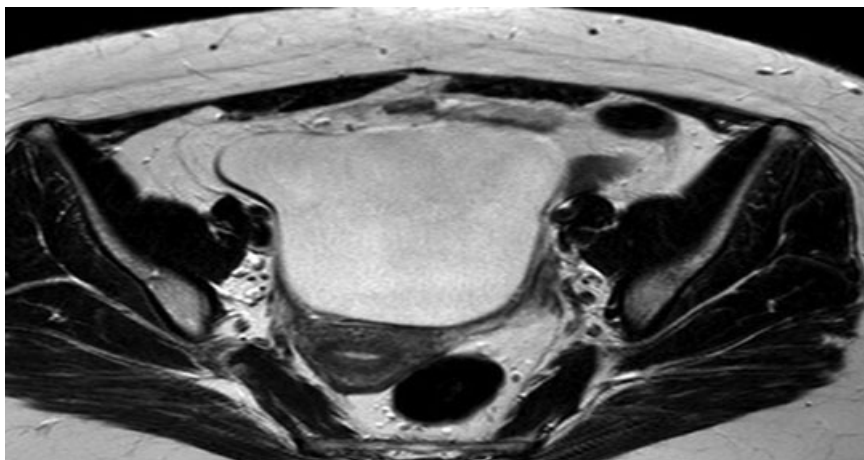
MRI of bladder showing small-bowel loops lying in front of bladder.
